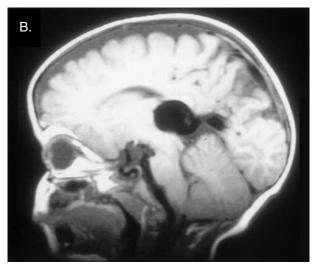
A*, Axial computed tomography demonstrates an area of high radiodensity (*arrow*) corresponding to thrombus in the dilated vein of Galen. *B*, Sagittal magnetic resonance imaging reveals a large flow void representing the dilated vein of Galen. *C*, Lateral view of vertebral artery angiogram reveals multiple arterial feeders to the vein of Galen malformation.
